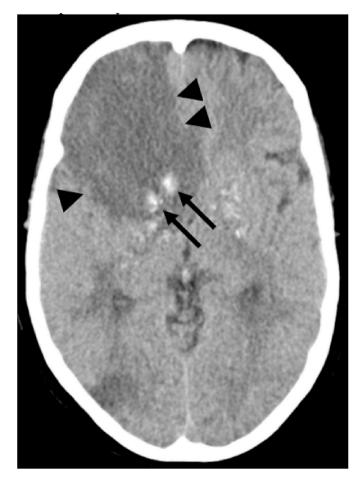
Axial non-contrast CT of the brain cerebrum that revealed subacute infarction (black arrowheads) in the right cerebrum with few areas of calcifications (black arrows).
